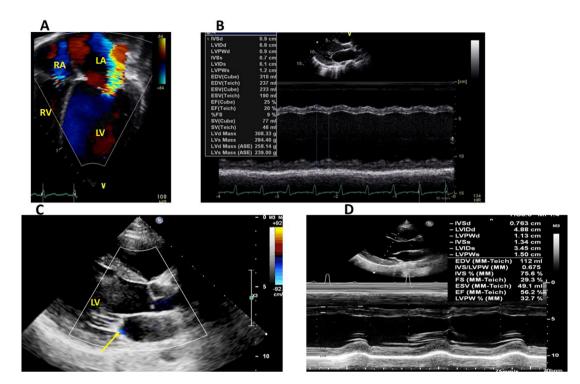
Echocardiography before and after L carnitine treatment. A: Apical four-chamber view before L carnitine therapy showing dilated LV, with moderate-severe mitral valve regurgitation. B: M—mode before L carnitine therapy showing LV dilatation with severe systolic dysfunction. C: Parasternal long axis view after L carnitine therapy with the reverse remodeling of LV with trivial mitral regurgitation (yellow arrow). D: M—mode after L carnitine therapy showing normal LV size and function. LA: left atrium, LV: left ventricle, RV: right ventricle, RA right atrium.
